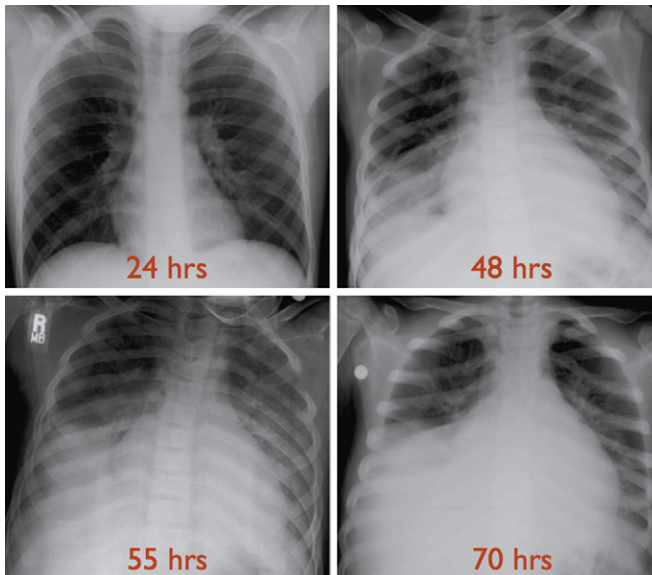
Rapid progression of acute chest syndrome. Serial chest radiographs of a 13-year-old male with homozygous sickle cell disease admitted for pain. Hours from admission are noted. Notably acute chest syndrome typically presents 2 to 3 days into an admission for a vaso-occlusive events.
